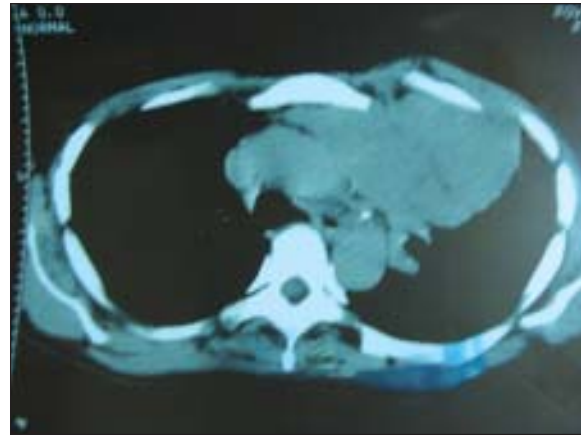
Computed Tomography scan shows lobulated mass in the anterior mediastinum.
